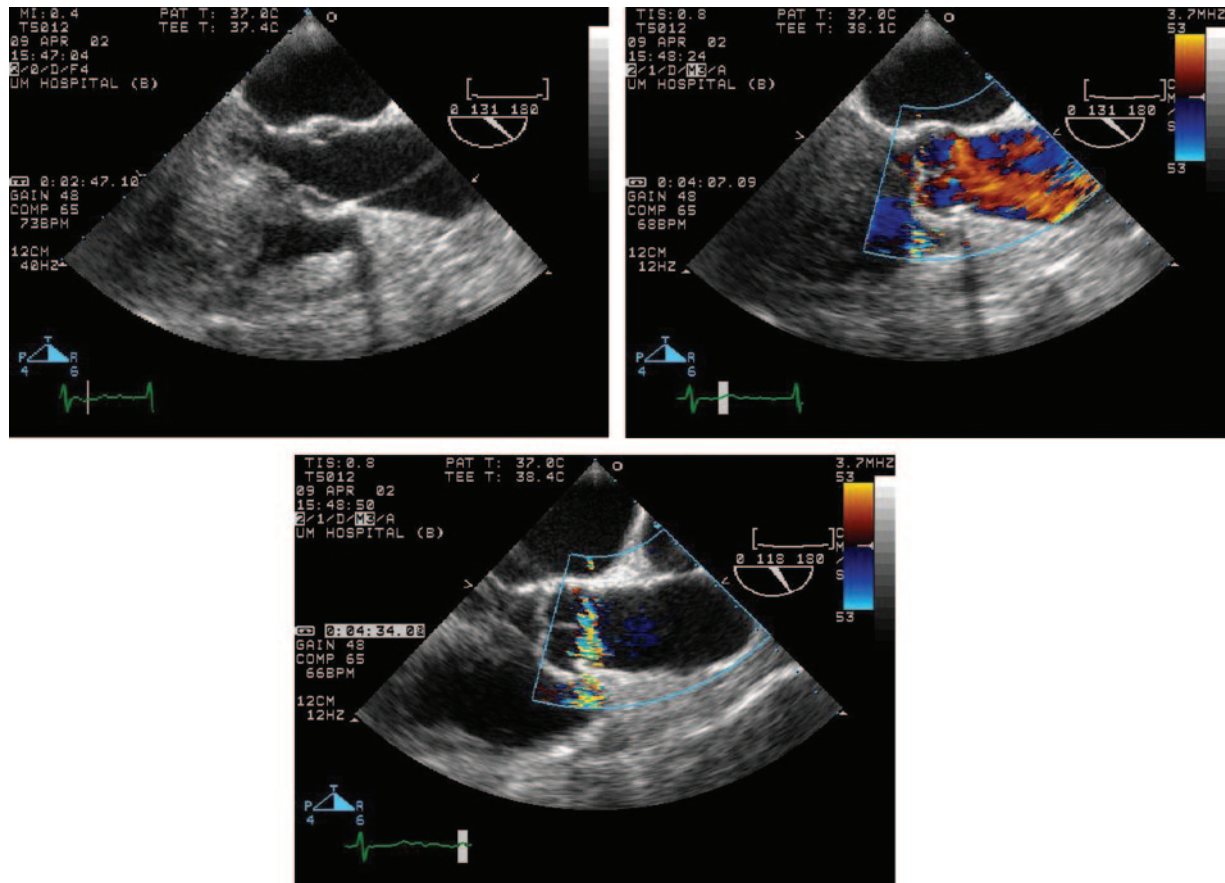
Artifact mimicking dissection. Top left, 2-dimensional view. Top right, Color-flow Doppler without margination. Bottom, Artifact not seen in this view.
